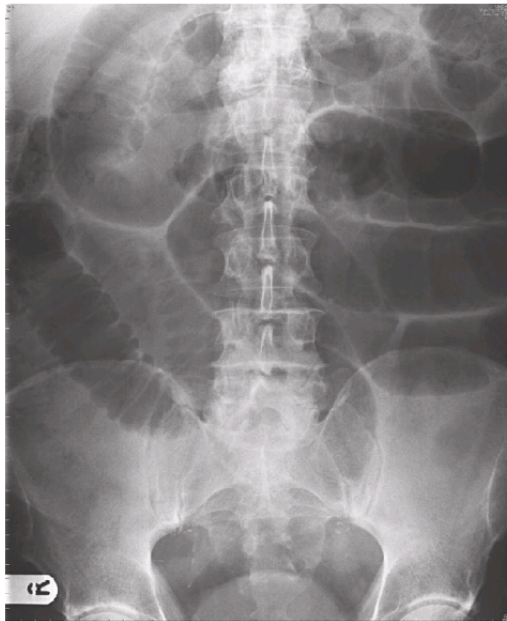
Plain x-ray of the abdomen.
